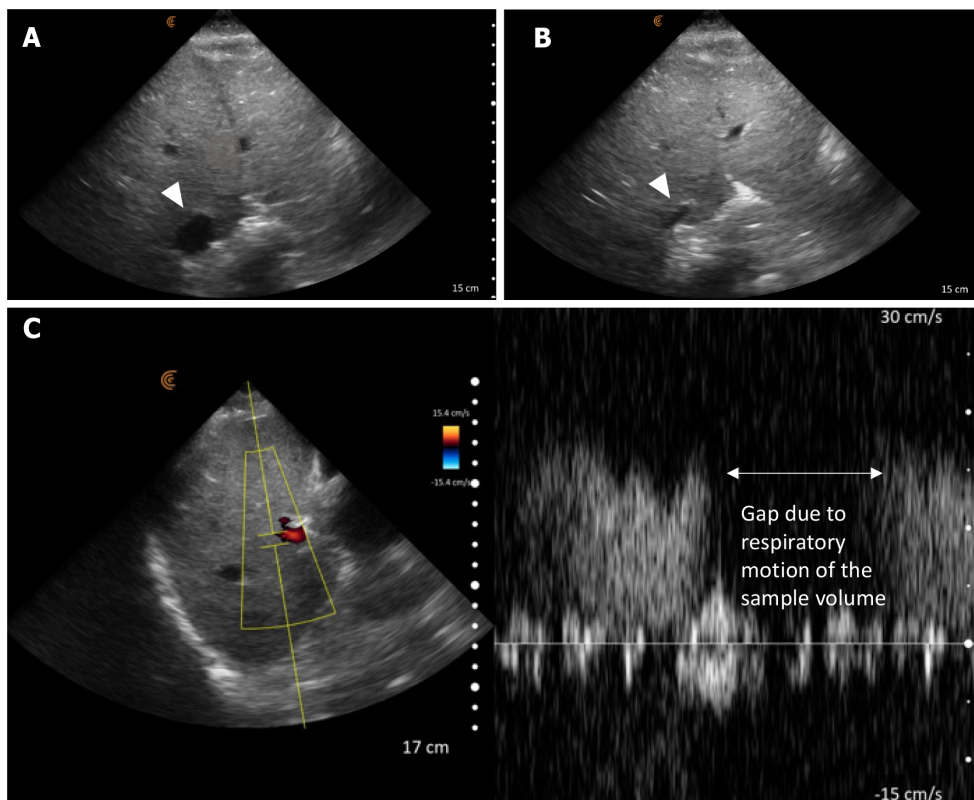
Follow up ultrasound examination demonstrating resolution of congestion. A: The inferior vena cava (indicated by the arrowhead) appearing elliptical in the transverse view with a decreased diameter compared to the initial examination; B: Near-complete collapse of the inferior vena cava (arrowhead) during a sniff, indicative of normal right atrial pressure; C: Continuous waveform observed in the portal vein on Doppler imaging.
